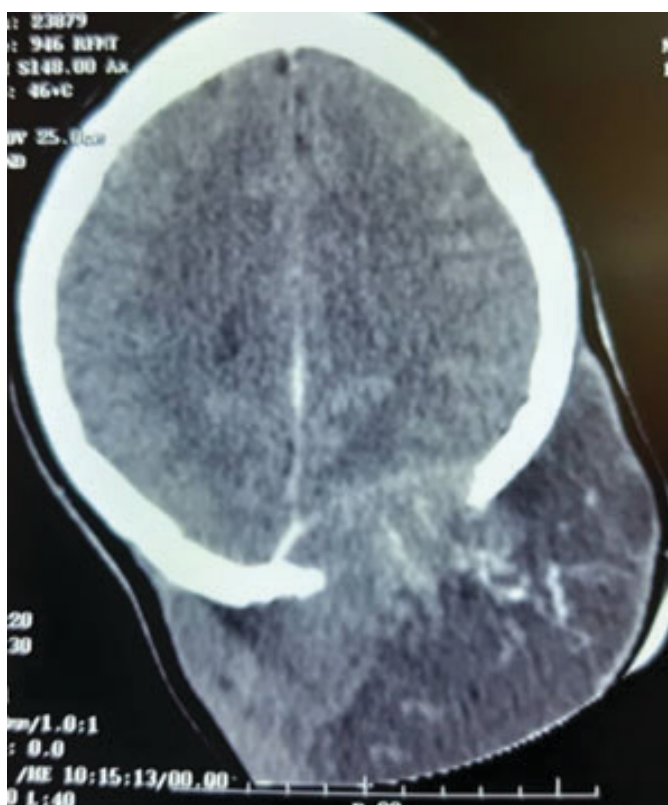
Contrast cranial CT of the lesion showing bony erosion.
